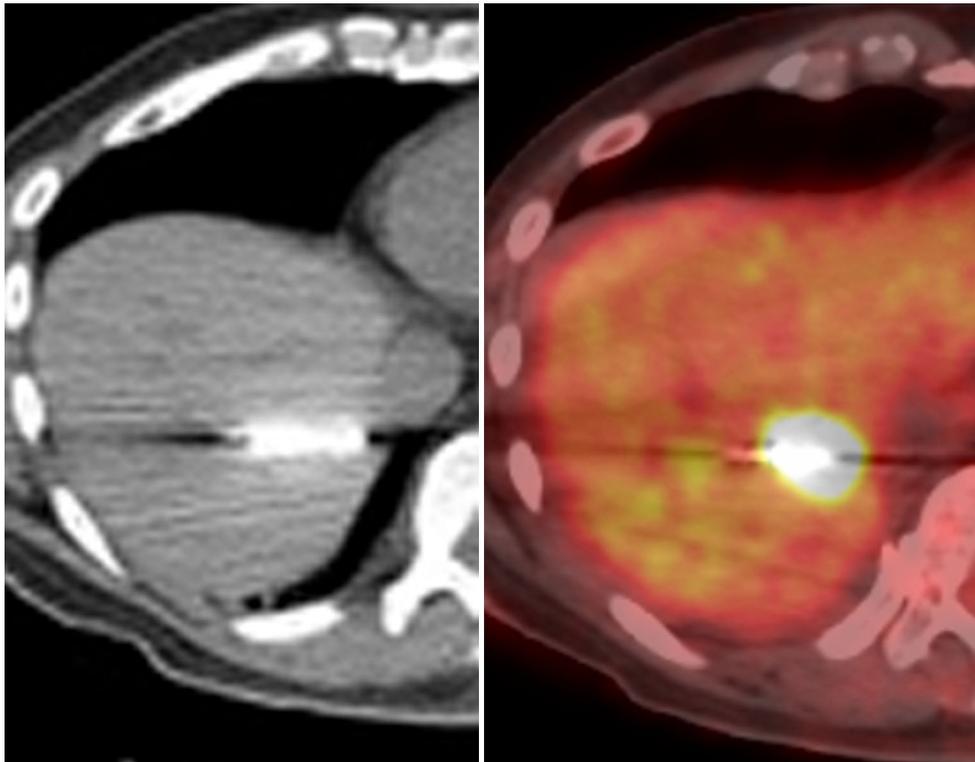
PET CT-guided MW ablation of segment 7
